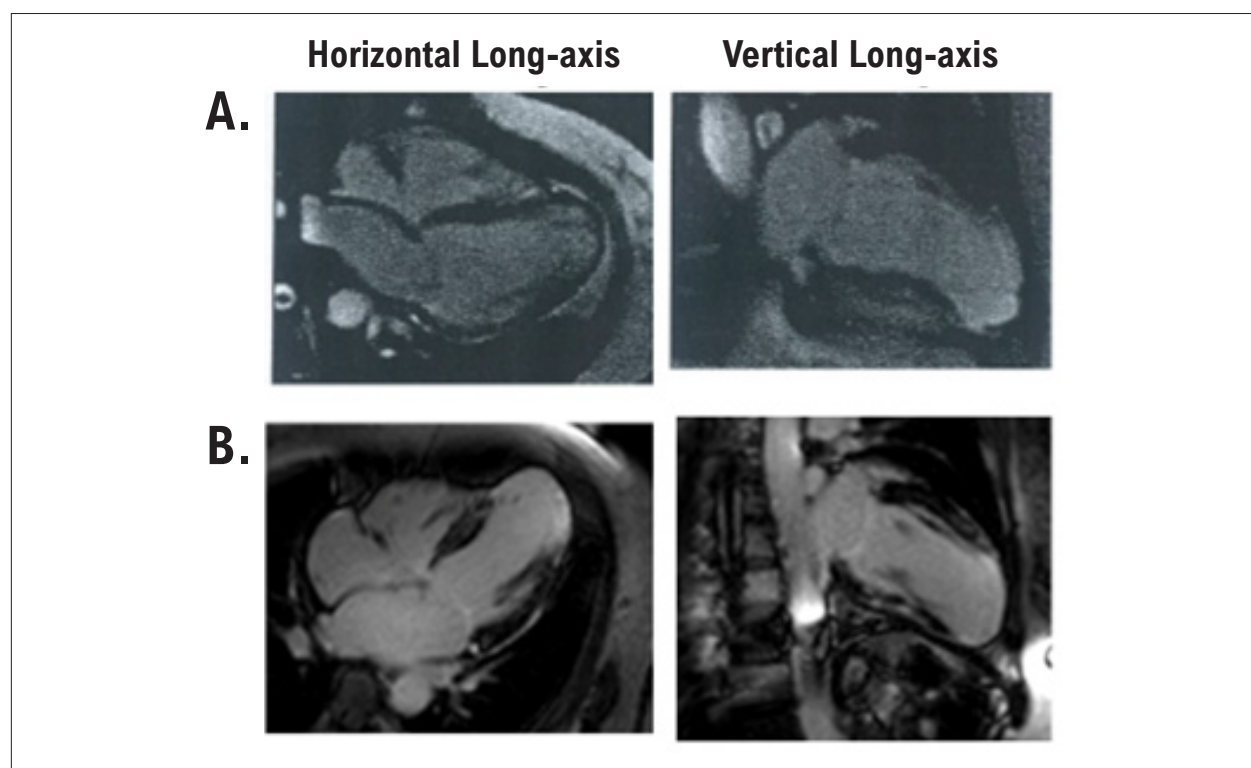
Cardiac magnetic resonance imaging of a patient with progressive changes in fibrosis mass. A) Myocardial delayed enhancement on horizontal and vertical long-axis slices depicts areas of midwall fibrosis (bright areas) in mid segments of the septum and transmural cardiac fibrosis in all apical walls and apex. Myocardial fibrosis mass was estimated in 33 grams. B) Myocardial delayed enhancement images obtained from the same patient 4.5 years later depict areas of midwall cardiac fibrosis in basal segments of inferoseptal, inferolateral, and anterolateral walls, mid segments of the septum and anterior walls, and transmural cardiac fibrosis in mid segments of inferolateral and anterolateral walls, all apical walls and apex. The estimated cardiac fibrosis mass increased to 58 grams.
